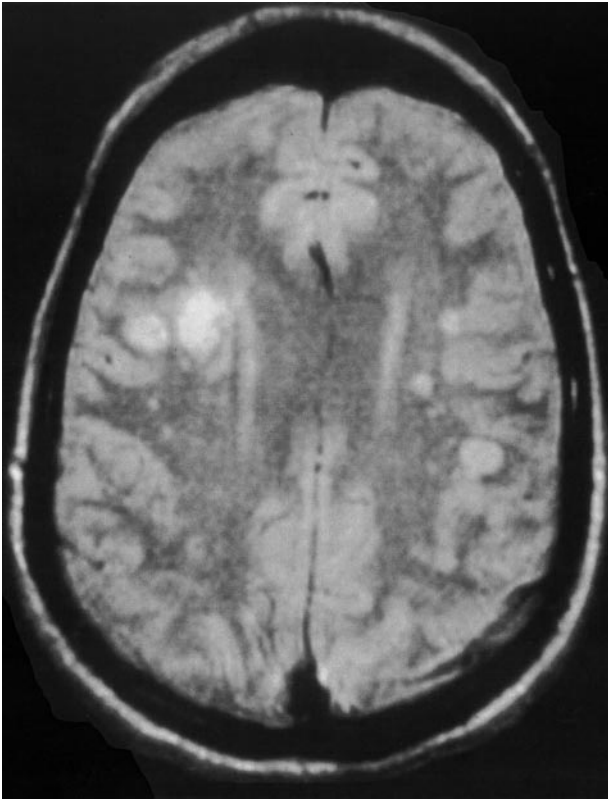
VZV multifocal vasculopathy. Proton-density brain MRI scan shows multiple areas of infarction in both hemispheres, particularly involving white matter and extending to gray-white matter junctions.
